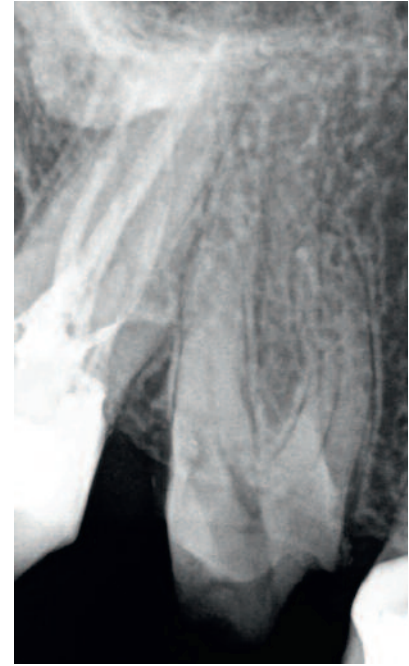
Radiographic examination at 6 weeks revealed reparative dentin formation and lack of any periapical pathology
